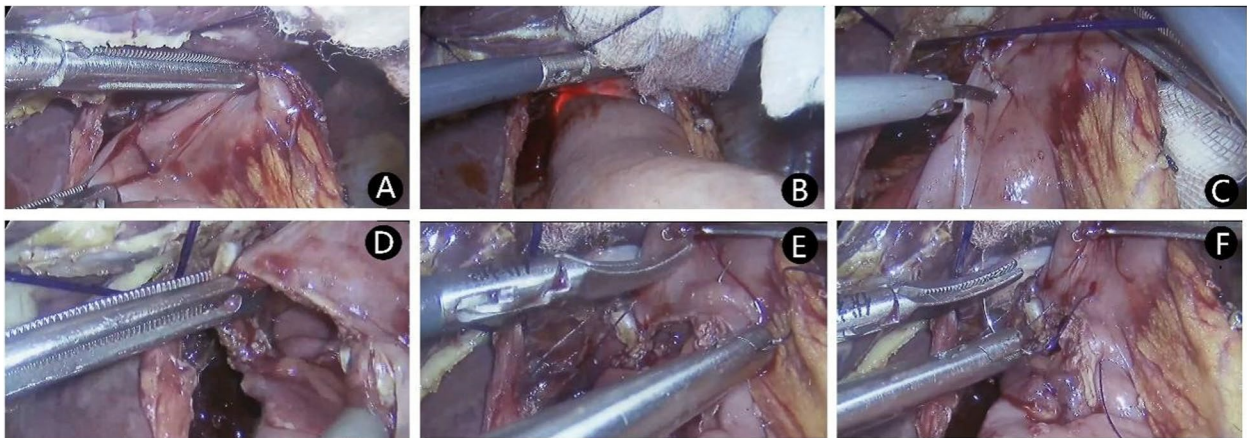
Intra-operative images of CASE 1 patient. A, B Intraoperative gastroscopy revealed anastomotic narrowing. C An incision was made on the jejunum side of Roux limb using an ultrasonic scalpel. D The anastomotic narrowing was opened and widened by releasing the sutured contralateral mucosa with the ultrasonic scalpel combined with electro-surgical hook. E, F The common entry of jejunum and esophagus was closed with a V-lock running suture
